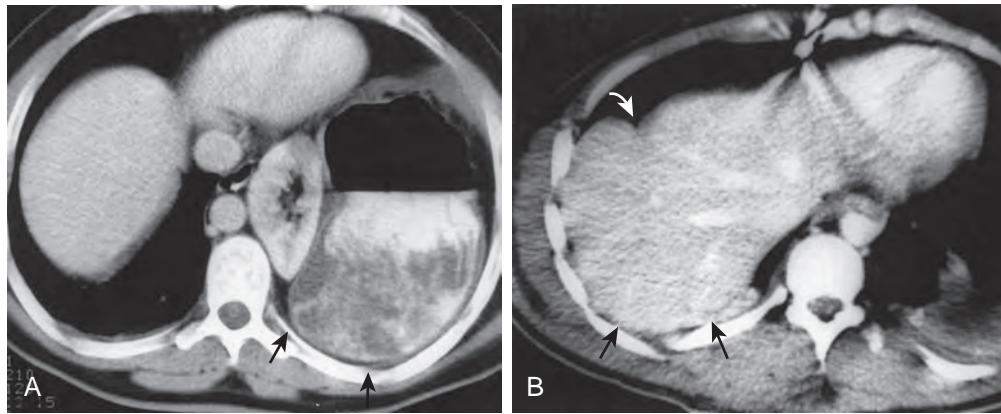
Traumatic diaphragmatic hernias: the dependent viscera sign. A. In a 32-year-old man with left-sided diaphragmatic rupture, an axial CT scan shows discontinuity of left hemidiaphragm (arrows indicate extent of diaphragmatic tear) with gastric and left renal herniation. The stomach lies dependent on left posterior ribs, which is a positive dependent viscera sign. B. In a 32-year-old woman with ruptured right hemidiaphragm, an axial CT scan shows the right lobe of the liver dependent on right posterior ribs (black arrows), which is the dependent viscera sign. A partial, waistlike constriction (white arrow)—the collar sign—is visible along anterior surface of right lobe of liver and is attributable to partial hepatic intrathoracic herniation. (A and B from Bergin D, Ennis R, Keogh C, et al: *The “dependent viscera” sign in CT diagnosis of blunt traumatic diaphragmatic rupture*. *AJR Am J Roentgenol* 177:1137-1140, 2001. Reprinted with permission from the American Journal of Roentgenology.)
